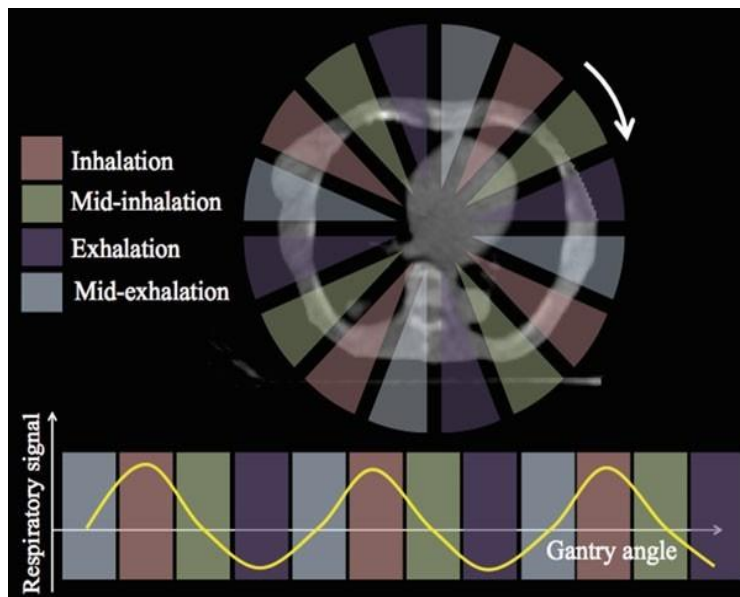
The reconstruction principle of 4DCBCT involves using projections acquired from 4 respiratory phases⁽⁴⁶⁾
